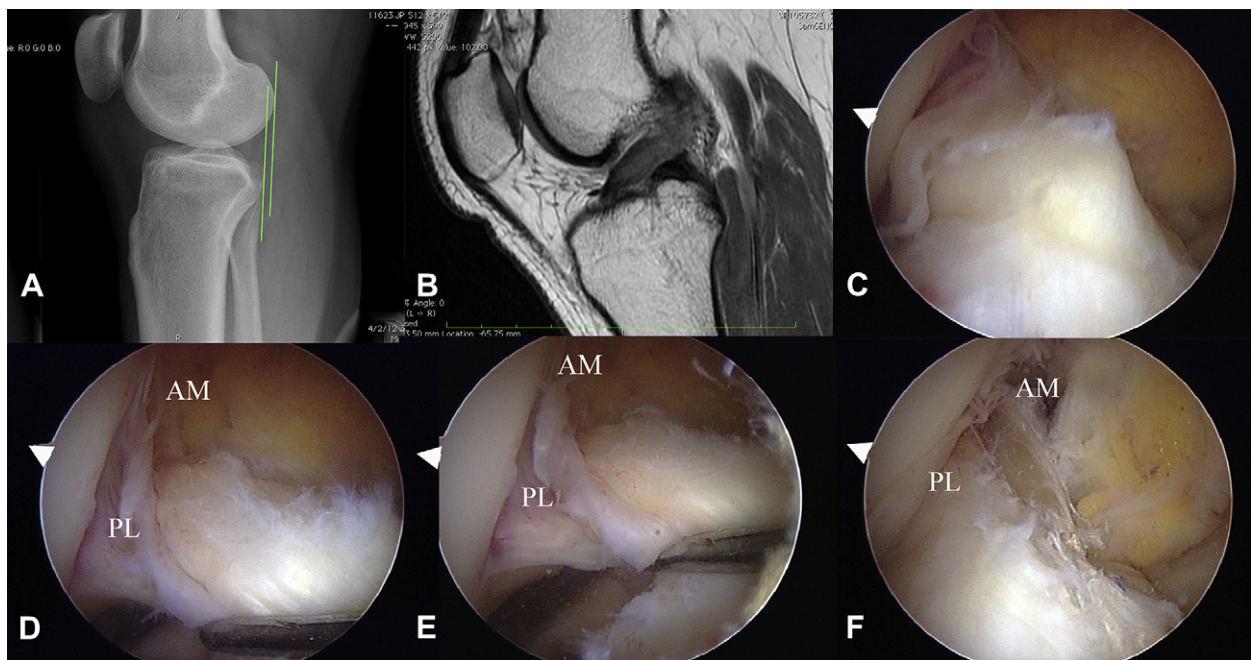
Example of a PL-intact case with functional remnant. (A) A minor side-to-side difference of 2 mm of anterior tibial translation by Telos stress radiography is recorded. (B) MRI findings show the presence of remaining fibers but without identifying the type of injury pattern. (C) Arthroscopy shows remaining fibers without being able to identify the injury type. (D) Evaluation of the integrity of the remaining fibers by stretching the fibers with the probe. (E) Certain partial tears require special maneuvers to confirm the mechanical integrity of the fibers in the figure-of-4 position; in this case the remaining fibers are solid and resist further stretching (i.e., functional). (F) AM bundle augmentation (left knee, view from anterolateral portal). (AM, anteromedial; PL, posterolateral.)
